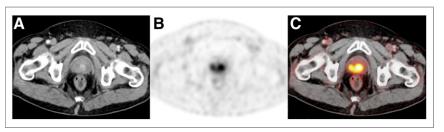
Multifocal local recurrence of PC in a 65-y-old patient (GS, 9; PSA nadir, 0.01 ng/mL after EBRT; staging PSA level, 3.8 ng/mL). CT (A) was negative, whereas PET (B) and fused PET/CT images (C) revealed multiple ⁶⁸Ga-PSMA ligand-positive lesions in prostate gland (SUV_{max}, 11.3). This finding was confirmed by transrectal ultrasonography-guided sextant biopsy.
